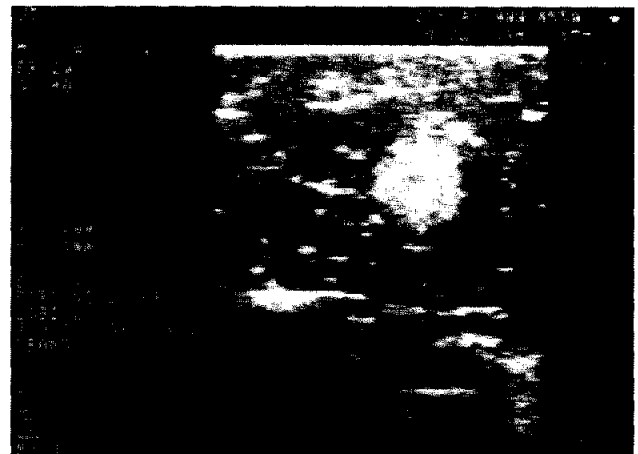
Ultrasound view of the agarose-based tumor-mimic.
